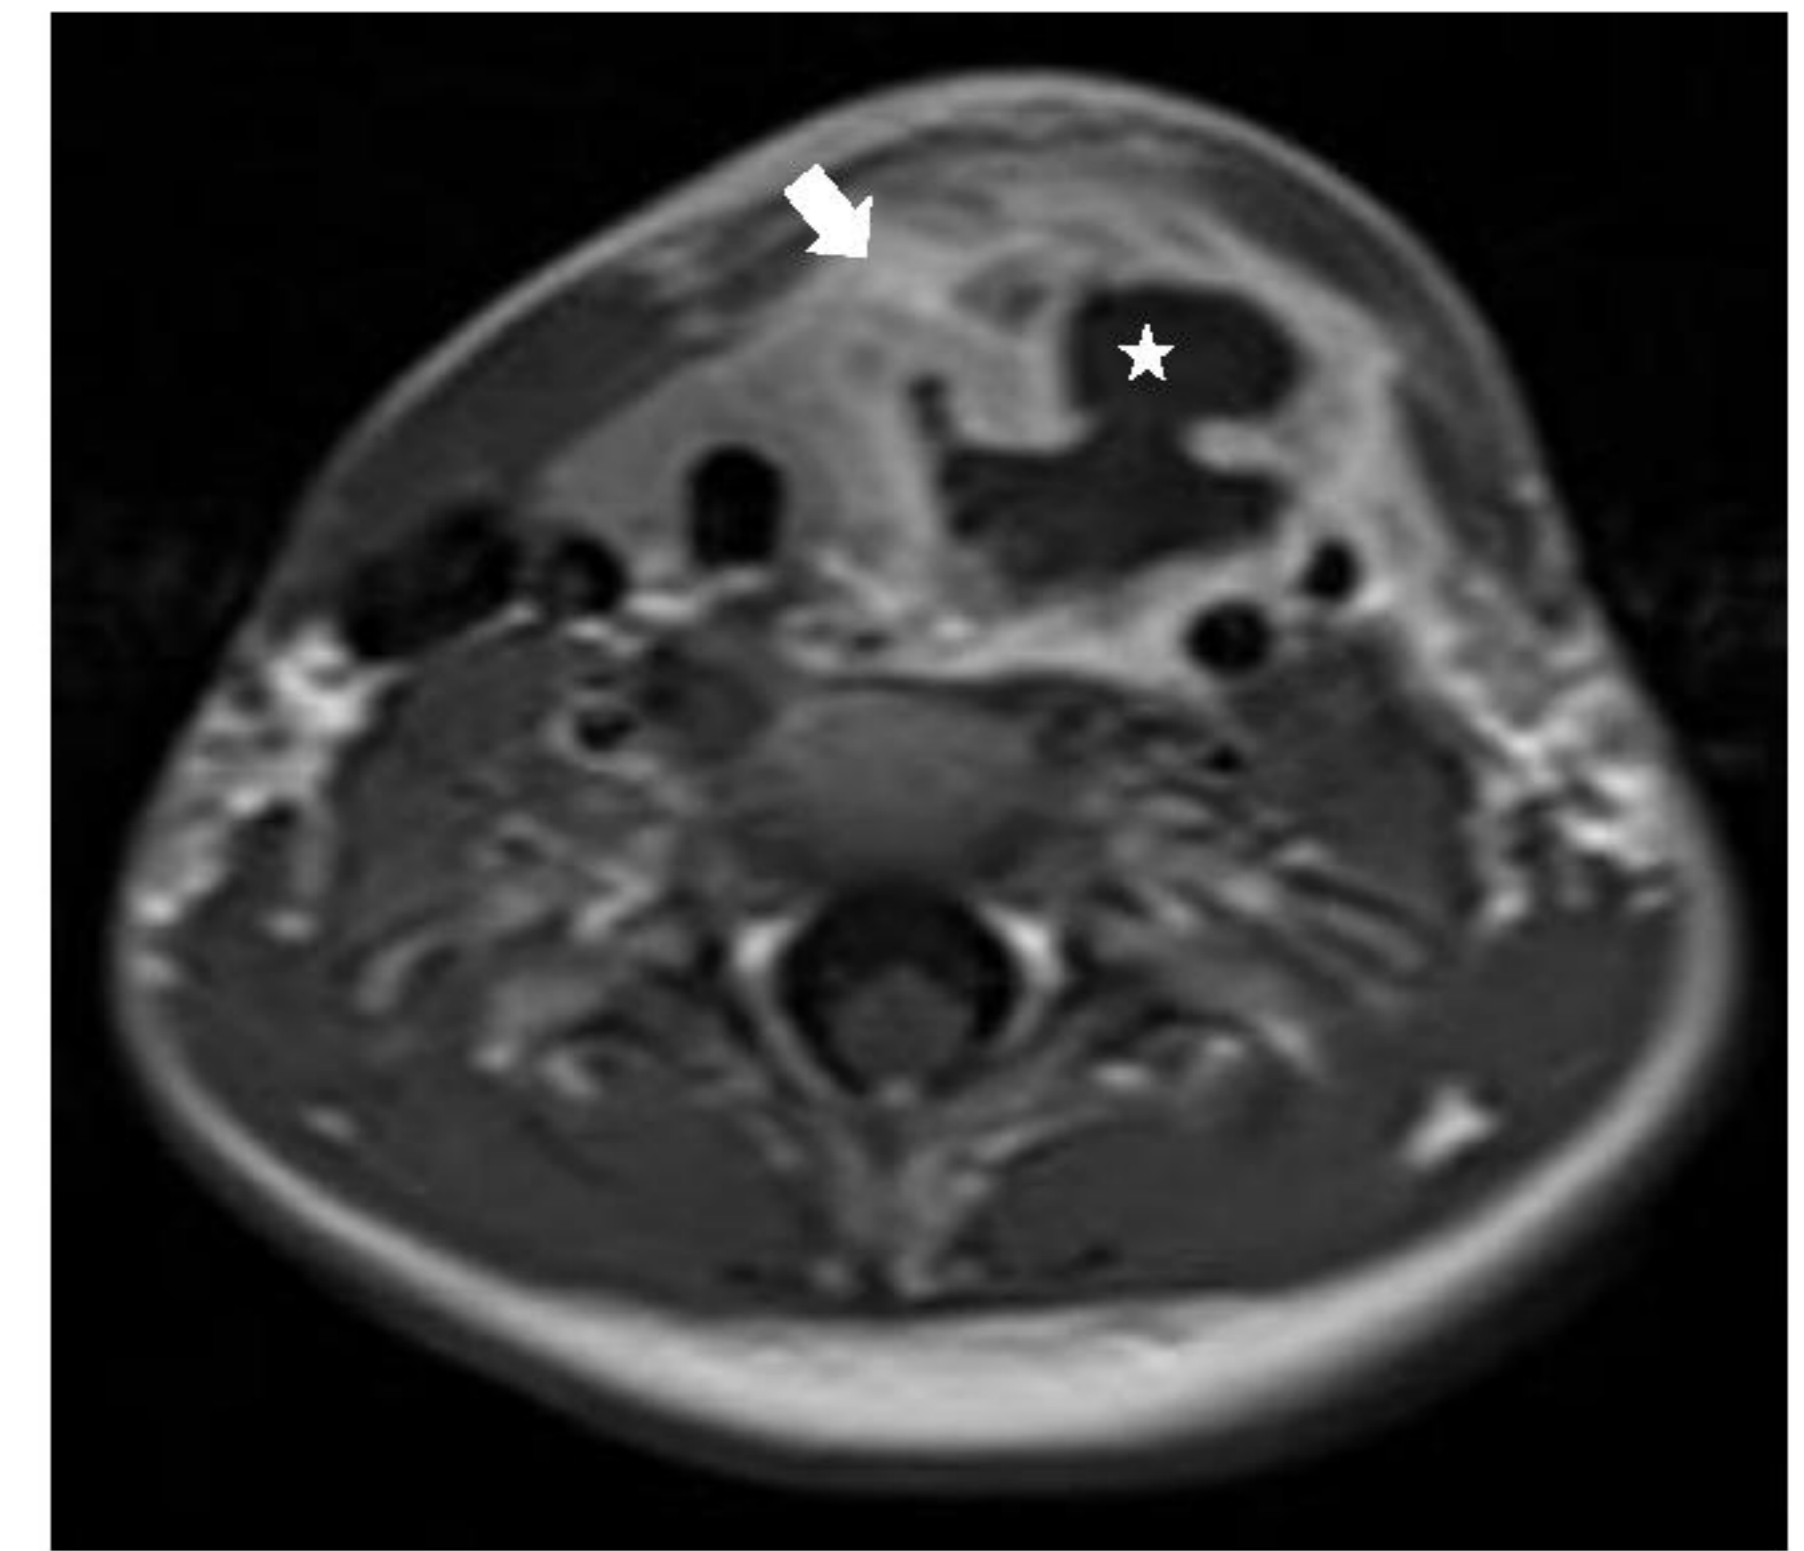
Post contrast-enhanced T1-weighted MRI demonstrates an irregular rim-enhancing abscess cavity (white star) extending to the swollen left thyroid gland (arrow).
